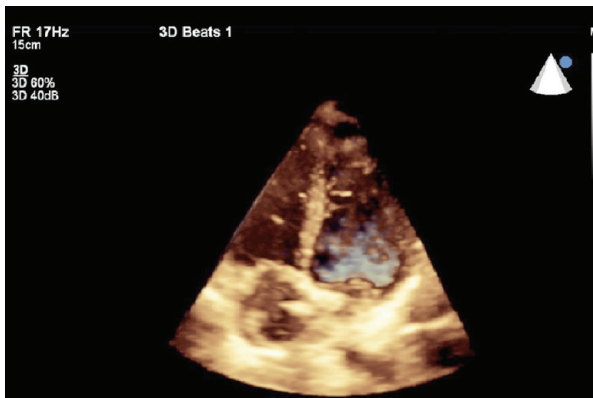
Appearance of the fibromuscular membrane on 3-dimensional echocardiogram.
